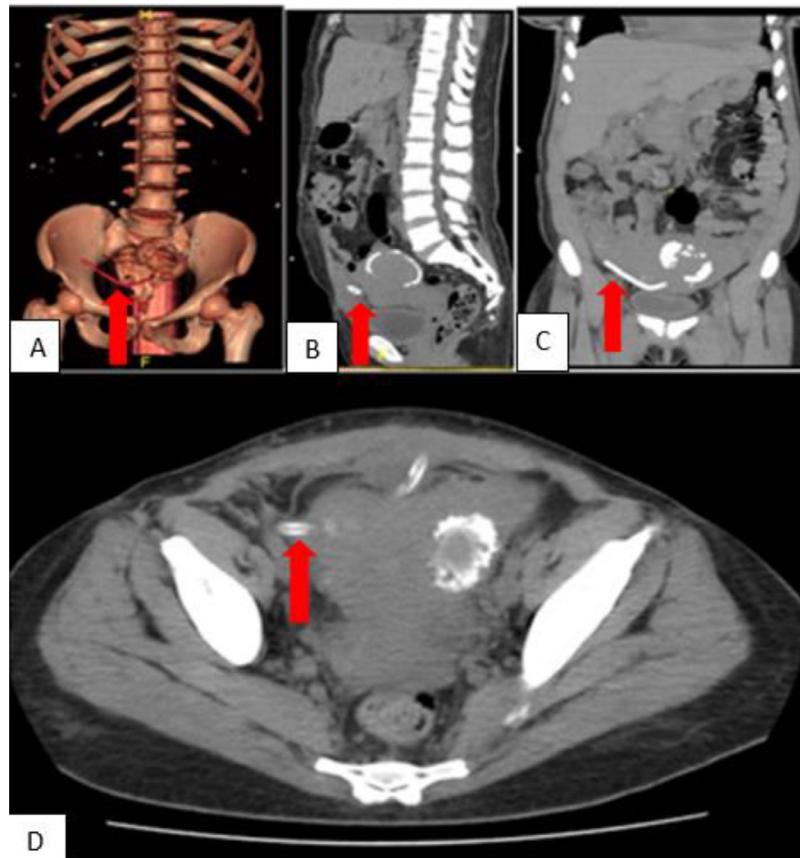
Unenhanced Abdominal & Pelvic CT scan, MPR images (A) 3D, (B) sagittal, (C) coronal and (D) axial views showing the retained fractured drainage tube (red arrows).
